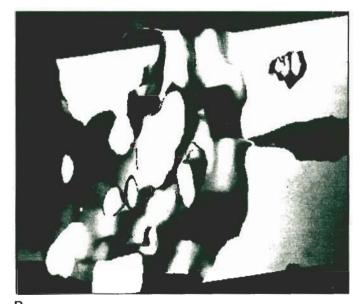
Postoperative complication. Axial CT through L5 (figure 13) demonstrates a large laminectomy defect. There are several fragments of bone in the spinal canal on the left.
